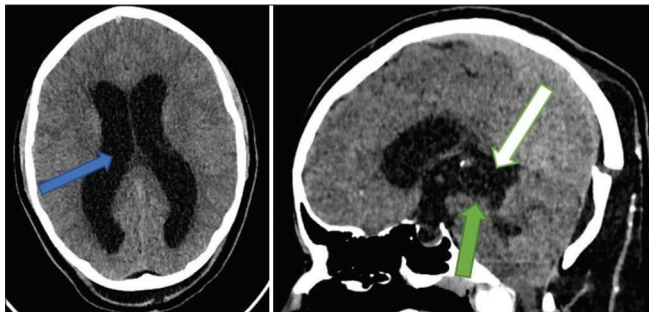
Day 10 CT scan showing features of hydrocephalus, that is, ventricular enlargement, compression of the basal cisterns, and convexity subarachnoid spaces (blue arrow). Compared to previous images, the cyst is obviously enlarged (white arrow) with compression of the cerebral aqueduct (green arrow).
